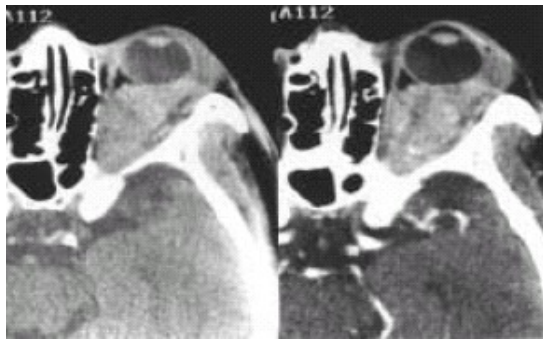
Non-contrast (right) and post-contrast computed tomography (CT) scans show the homogenous soft tissue mass adherent to the ocular wall extending from the anterior to posterior of the globe.
